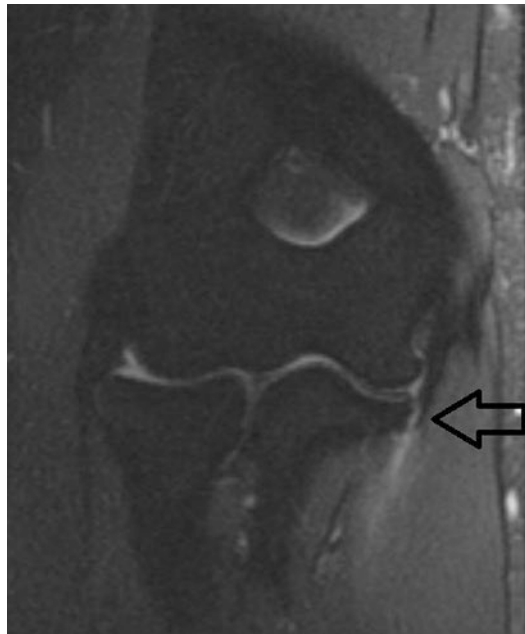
MRI scan indicating a distal tear of the UCL at the sublime tubercle (arrow)
